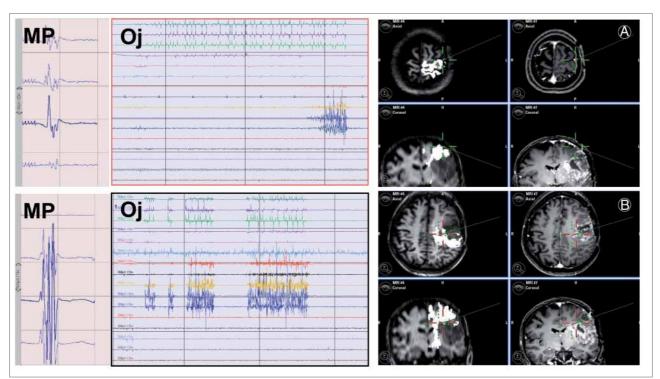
Example of integration of intraoperative neurophysiology with advanced MR imaging (DTI-FT) in a case of a left rolandic tumour. In this case, at the beginning of the resection the surgeon should integrate information coming from DES cortical mapping (a) (left and middle panel showing hand motor responses from the hand obtained by train of 5 techniques [left panel]) and 60 Hz probes [middle panel]), to those obtained by DTI-FT. The right panel shows the DTI-FT reconstruction for CST (in white) superimposed onto post-contrast T1-weighted images. The green cross indicates the position of the cortex where DES found hand motor responses. The site corresponded to the CST as indicated by DTI-FT images. The same type of integration is shown during resection at the subcortical level (b). The green cross indicates the site where DES (with both train of 5 techniques and 60 Hz) located hand responses from the subcortical of the CST, which corresponded to the same position in the DTI-FT images.
